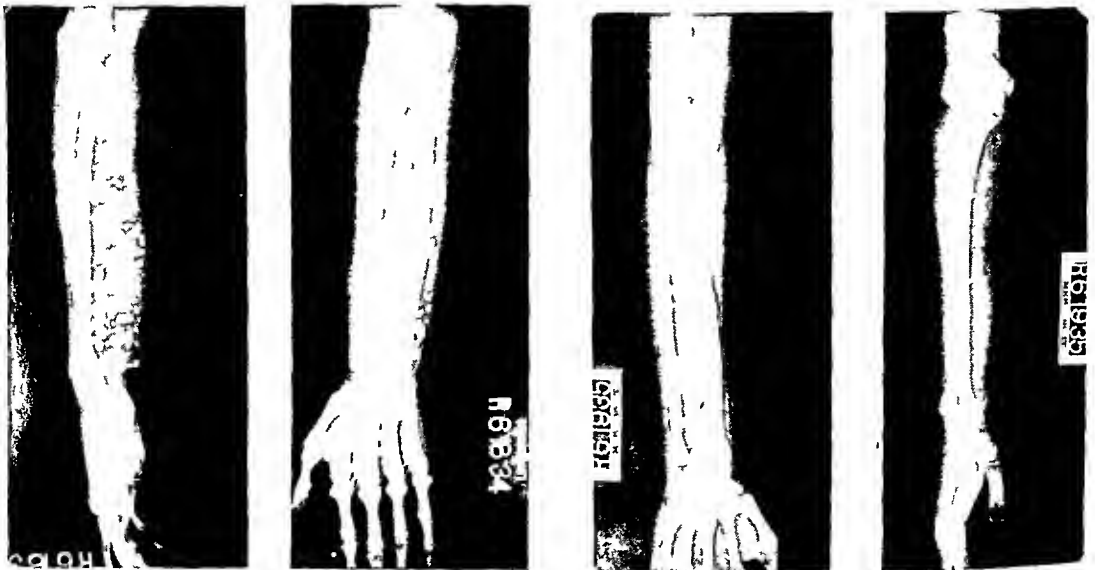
Case 16 Roentgenograms of right arm before and after operation
